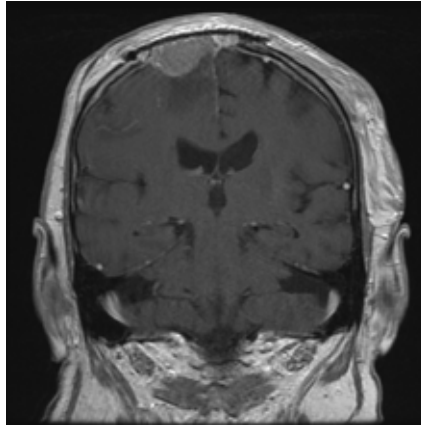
Magnetic resonance imaging head showing recurrent anaplastic meningioma.
